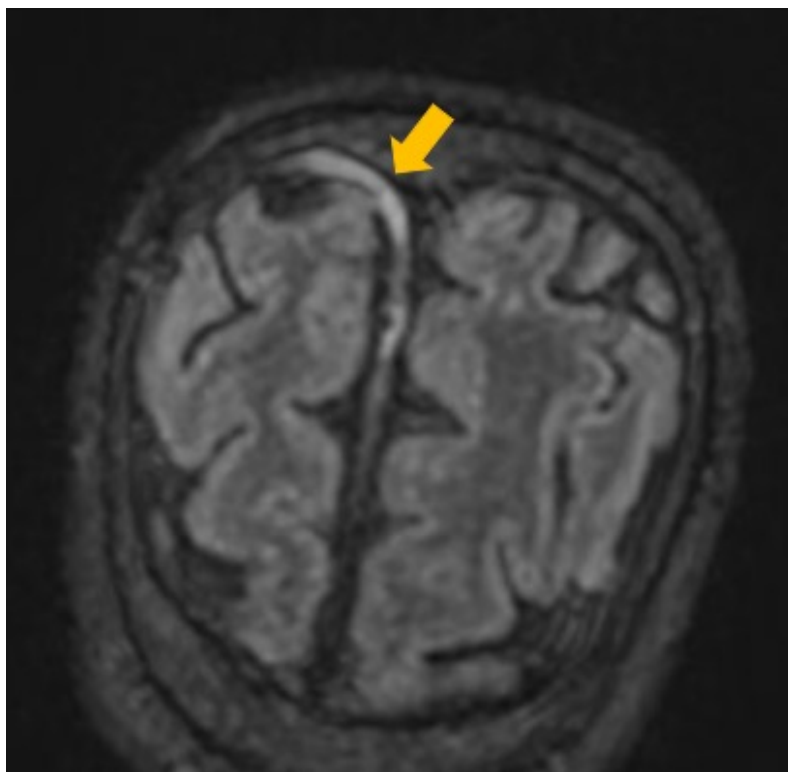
Contrast-enhanced MRI brain of a 14-year-old boy with acute myeloblastic leukaemia [6]. He had invasive fungal infection involving the right nasal cavity and maxillary sinus. Contrast-enhanced MRI shows increased dural enhancement along the right frontal anterior falx (arrow), suggestive of intracranial extension of infection.
